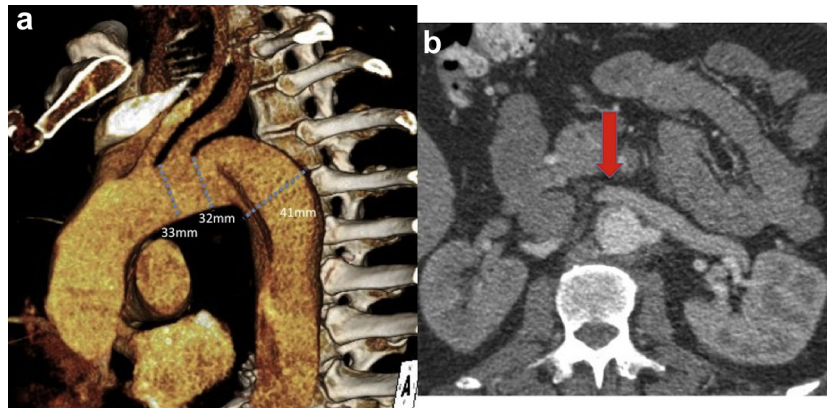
Computed tomography scan demonstrating (a) a type B dissection of the thoraco-abdominal aorta encroaching the left subclavian artery (LSA) and (b) true lumen collapse at the level of the renal arteries (*arrow*) causing malperfusion of the right renal artery.
